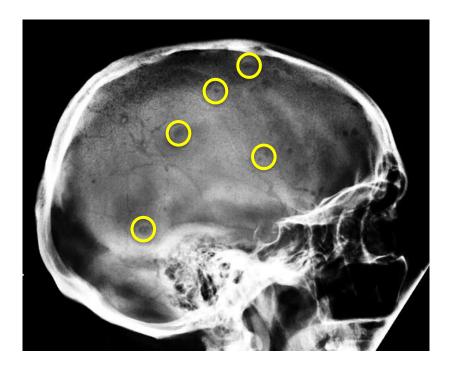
A lateral radiograph of the skull demonstrating numerous osteolytic myeloma lesions.
